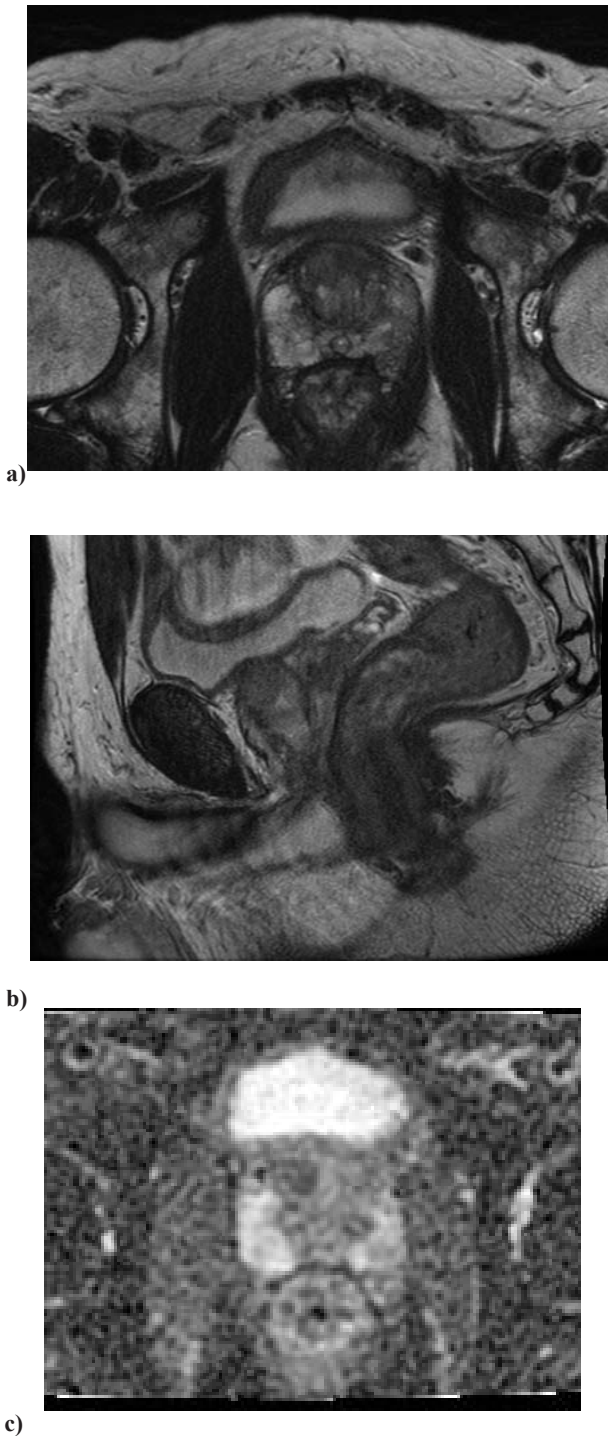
mpMRI showing a suspicious 2 cm PIRADS 4 lesion in the anterior region of the transitional zone at right base and mid gland. T2 axial (a), T2 sagittal (b), and diffusion weighted DWI axial images (c)
